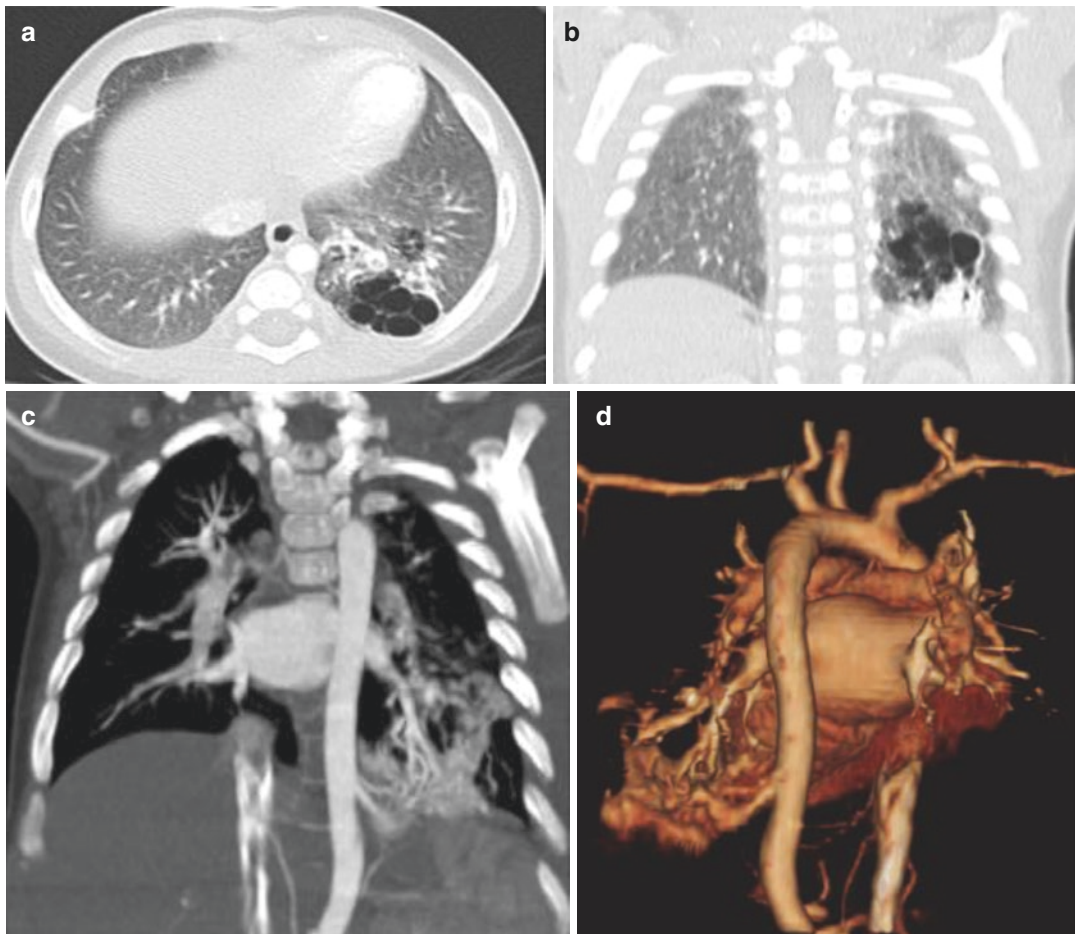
6 Patient with intralobar Sequestration. CT angiography (a) coronal MIP (maximum intensity projection); (b) coronal volume rendering reconstruction. Small
